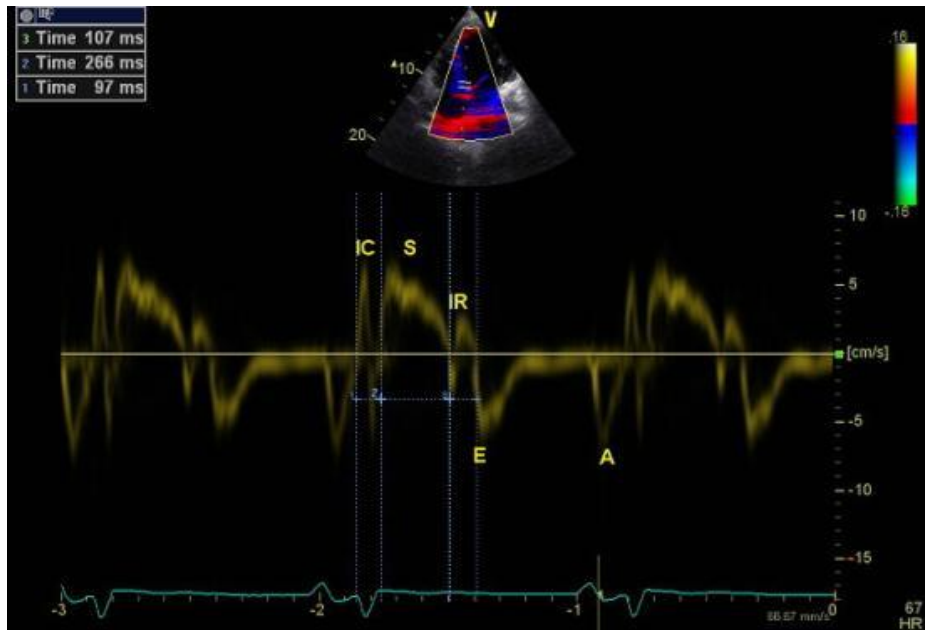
TDI Measurements recorded at the septal mitral annulus in the apical four- chamber view: ICT [ICT: end of A' wave to start of S wave] and isovolumic relaxation time (IRT: end of S wave to start of E' wave), Tei index (Myocardial Performance Index) was calculated by adding ICT plus IRT divided on the S wave duration (ICT +IVR/ S wave duration) from TDI
